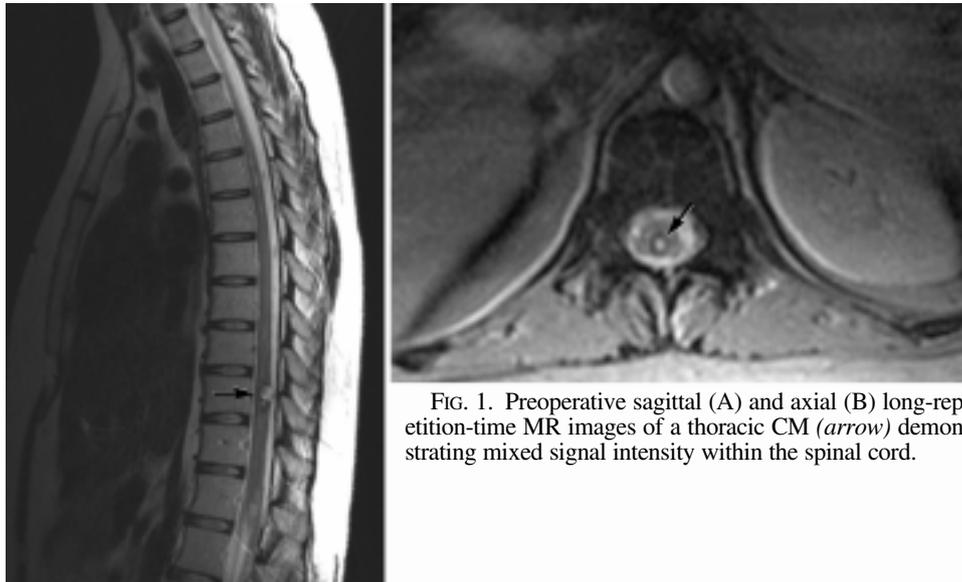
Preoperative sagittal (A) and axial (B) long-repetition-time MR images of a thoracic CM (arrow) demonstrating mixed signal intensity within the spinal cord.
